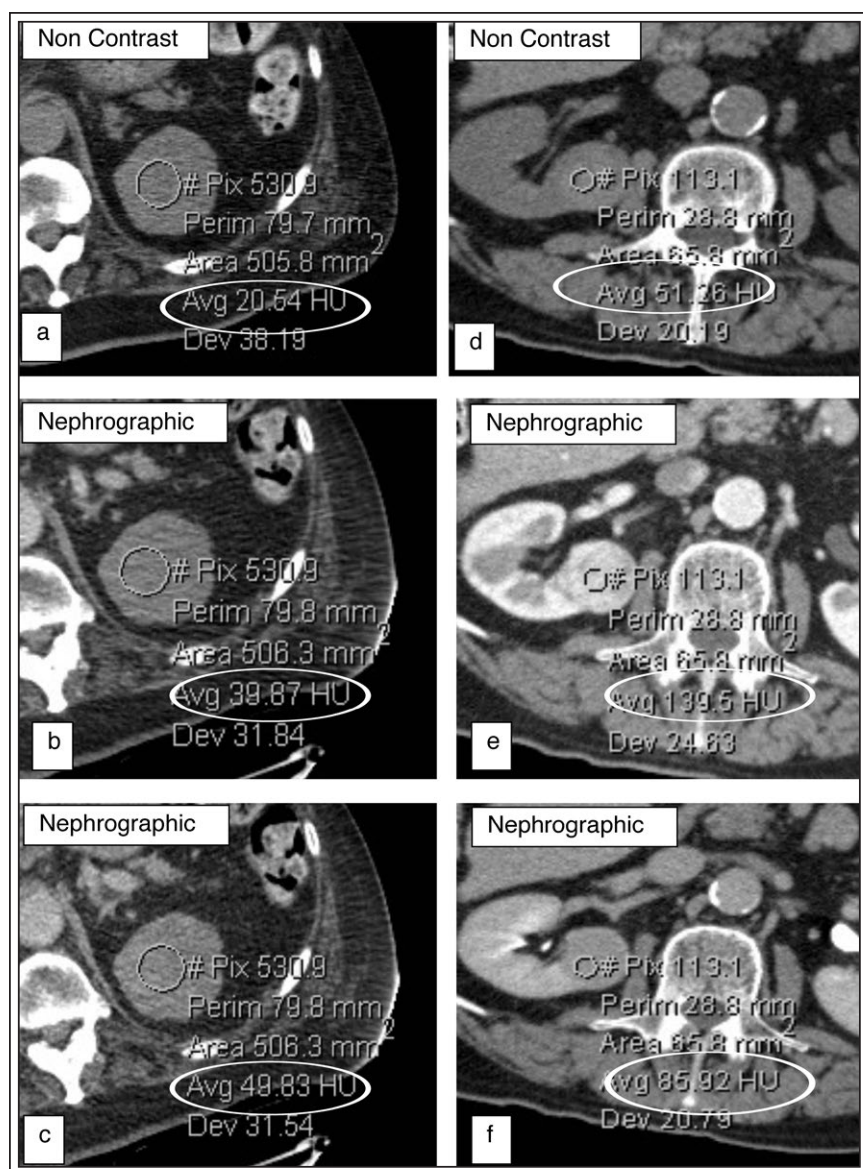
[HU in the ellipsoid in each image]. a) 69-year-old male with left papillary renal cell carcinoma. Non-contrast CT demonstrates mass to measure 20 HU; b) after contrast administration, the mass progressively enhances from 39 HU on nephrographic scan, and then c) to 49 HU on 3 minute delayed image. The enhancement washout of this mass equals $(\text{Mass Nephrographic HU} - \text{Mass Delayed HU}) / (\text{Mass Nephrographic HU} - \text{Mass Non-contrast HU}) = 39 - 49 / 39 - 20 = -0.5$; d) 63-year-old male with right clear cell renal cell carcinoma. Non-contrast CT demonstrates right renal mass to measure 51 HU; e) the mass achieves maximal enhancement at nephrographic CT scan measuring 139 HU, with significant washout by 3 minute delayed image when it measures 85 HU; f) the enhancement washout of this mass equals $139 - 85 / 139 - 51 = 0.6$
